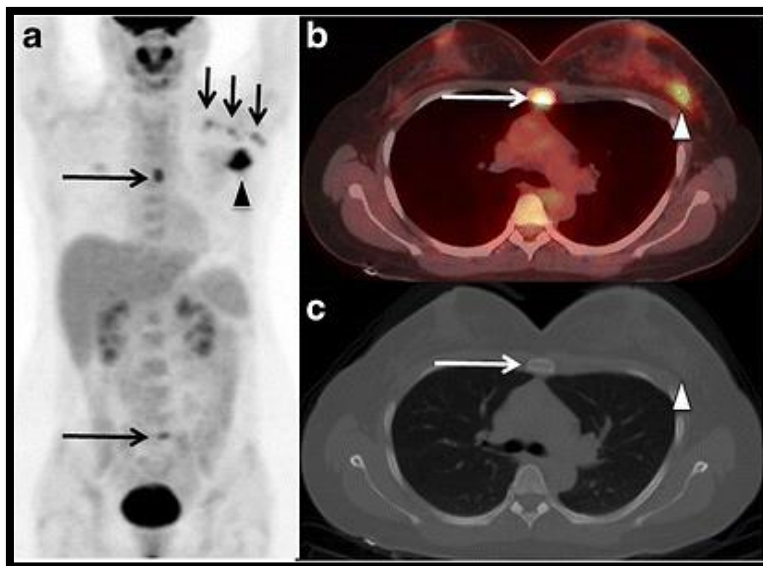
A 32-year-old woman with clinical stage IIB breast cancer was upstaged to stage IV after performing PET/CT. The arrowhead shows a. known primary breast cancer, short arrows show known axillary nodal metastases, and long arrows are two foci of FDG uptake in the midline of body. b. Axial PET/CT and c. axial CT through the chest showed primary breast cancer (arrowhead) and localized one of the midline foci to sternum without osteolytic or osteosclerotic correlate on CT (long arrows). Biopsy of sternum demonstrated osseous metastasis unknown before PET/CT. The second midline focus was subsequently proven to be sacral metastasis (not shown) (23).
